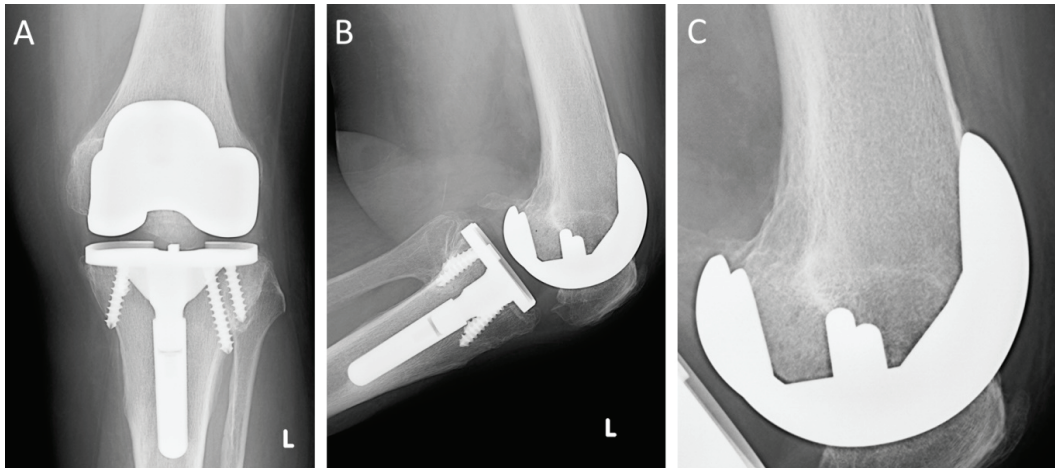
Translucency adjacent to the femoral component in an asymptomatic patient on an 8-year postoperative x-ray. A- anteroposterior image of the left knee; B- laterolateral image of the left knee; C- enlarged femoral part from image B with obvious translucency.
